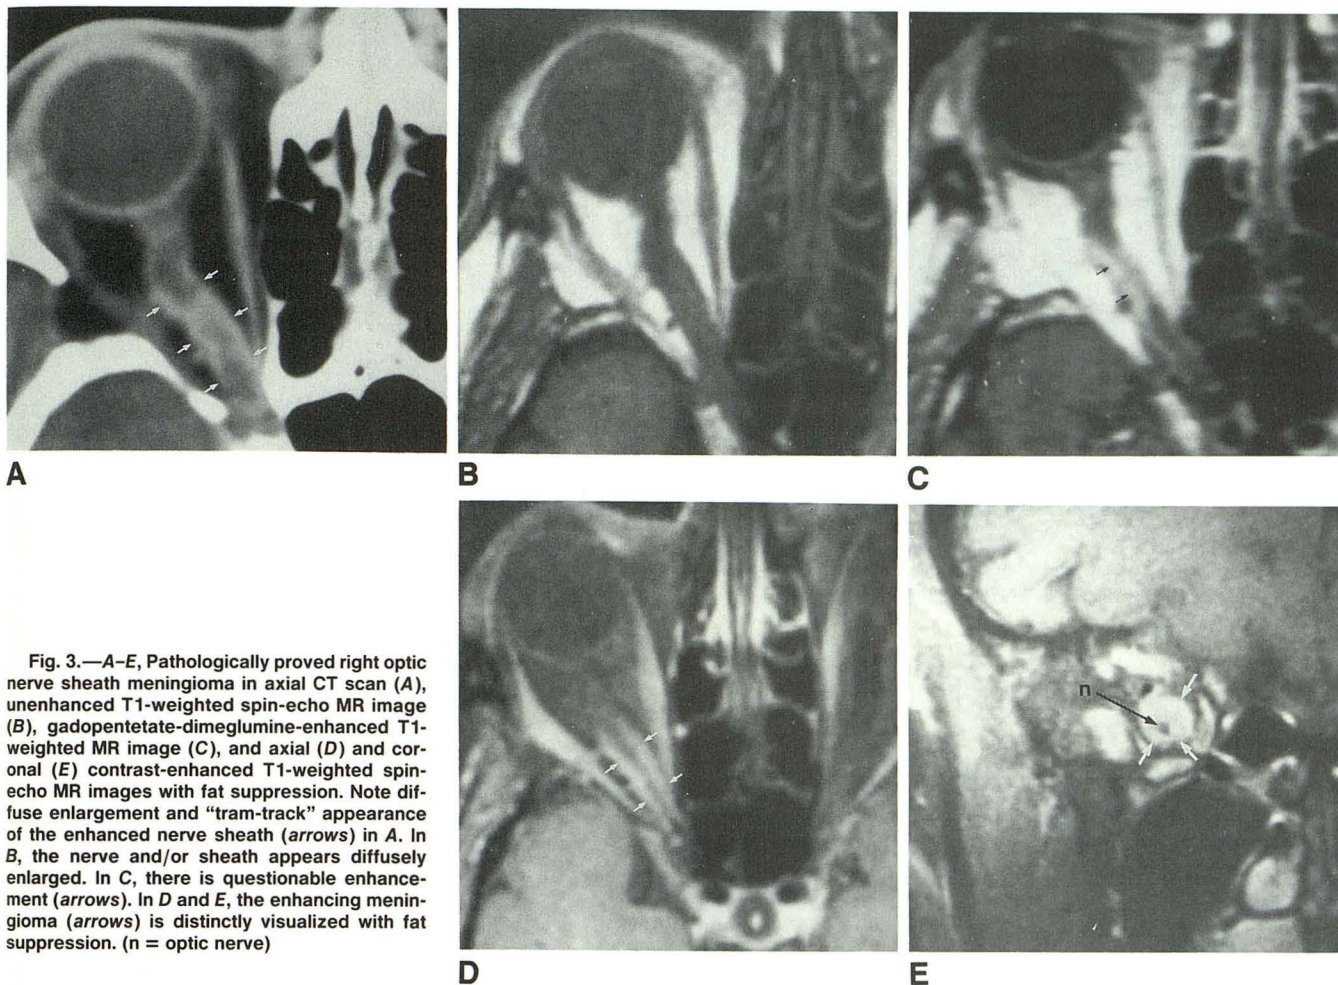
A–E, Pathologically proved right optic nerve sheath meningioma in axial CT scan (A), unenhanced T1-weighted spin-echo MR image (B), gadopentetate-dimeglumine-enhanced T1-weighted MR image (C), and axial (D) and coronal (E) contrast-enhanced T1-weighted spin-echo MR images with fat suppression. Note diffuse enlargement and “tram-track” appearance of the enhanced nerve sheath (arrows) in A. In B, the nerve and/or sheath appears diffusely enlarged. In C, there is questionable enhancement (arrows). In D and E, the enhancing meningioma (arrows) is distinctly visualized with fat suppression. (n = optic nerve)
